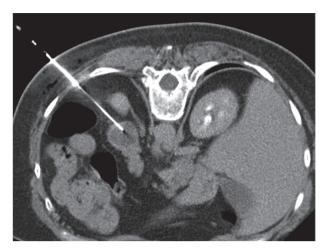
A 65 years old woman with abdominal pain; the abdominal CT demonstrate a pancreatic tail lesion. CT-guided PNB on prone position of pancreatic tail lesion showed a neuroendocrine tumor
